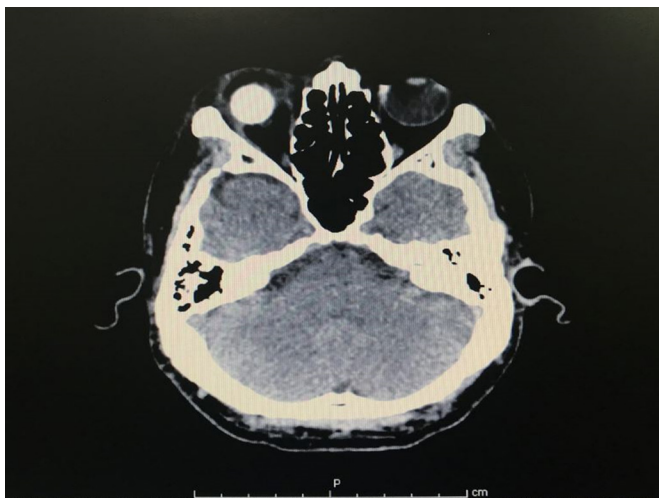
CT brain with contrast media (CM)
